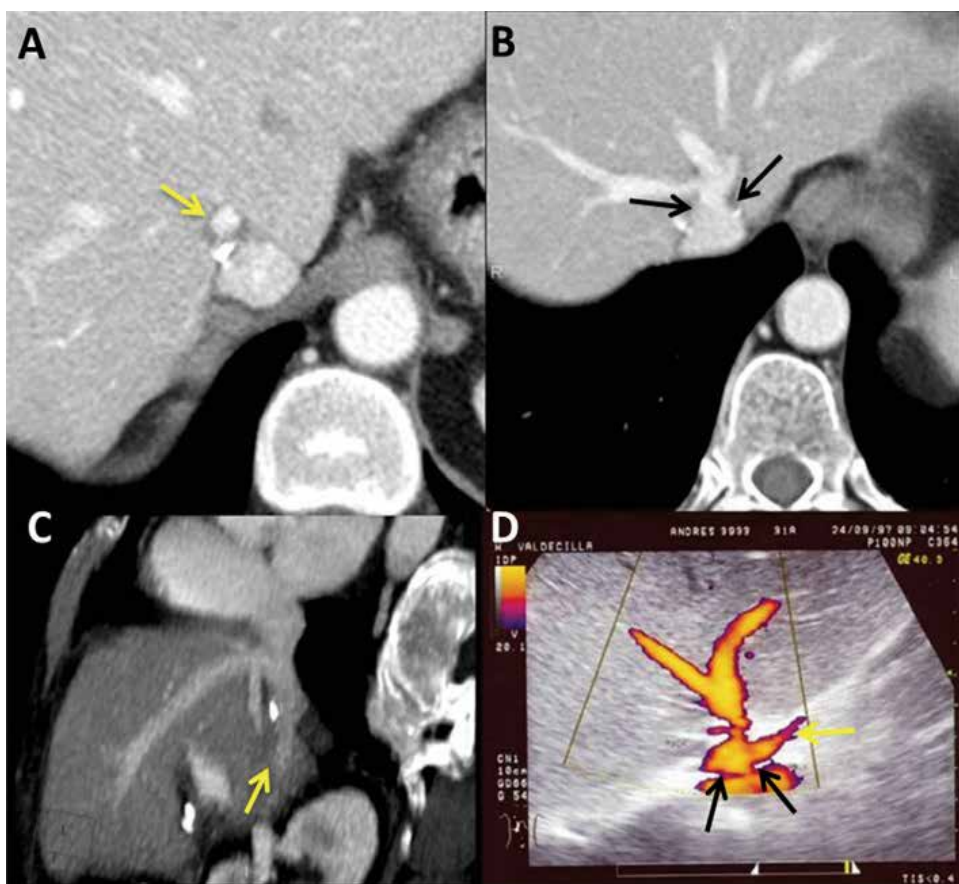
Duplex-Doppler and CT Image showing the appearance of the normal caval stump. Yellow arrows pointing normal appearance of the graft caval stump and the black ones show the caval anastomotic outlet with adequate graft venous outflow drainage
